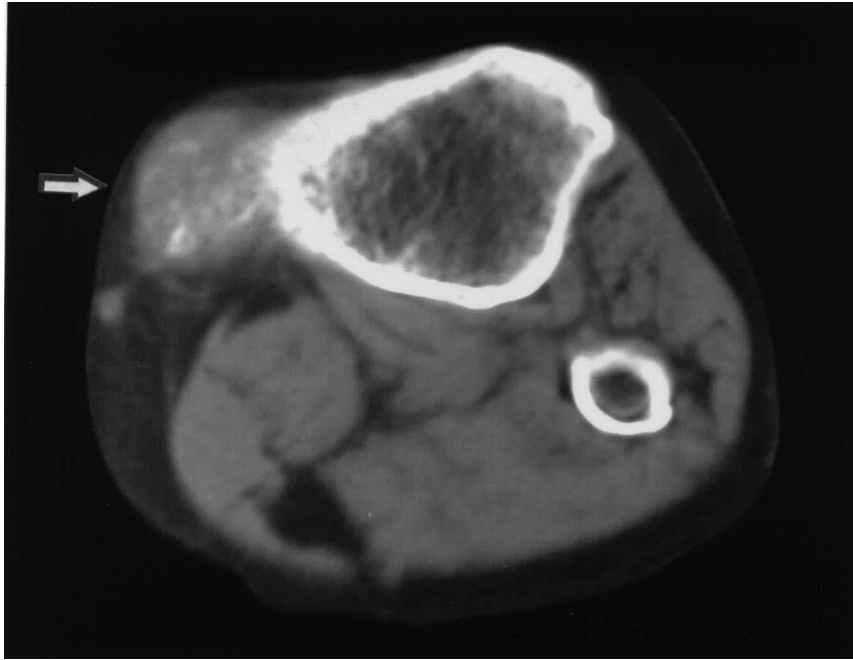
Computed tomogram showing calcification (arrow) inside the tumor.
